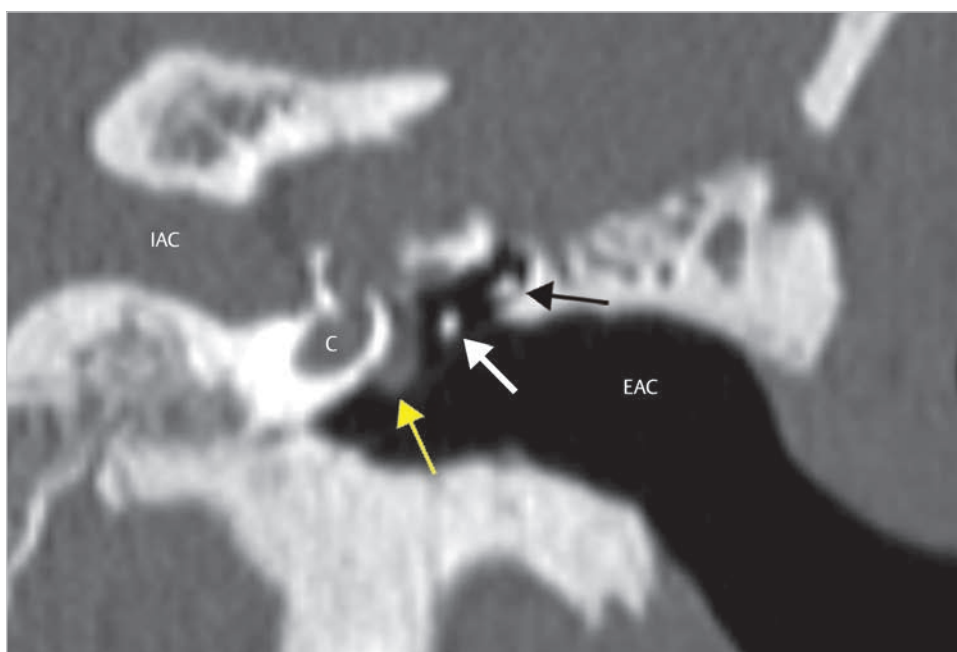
Coronal CT at the level of the short process of the incus (*black arrow*) and the incudostapedial joint (*white arrow*) show extensive loss of bone at the level of the cochlea and the fundus of the internal auditory canal. The cholesteatoma protruding from eroded medial wall of the tympanic cavity covering the promontory is seen (*yellow arrow*). A bone flap replaced over the middle fossa is identified (*black arrow*). C, cochlea; EAC, external auditory canal; IAC, internal auditory canal.
